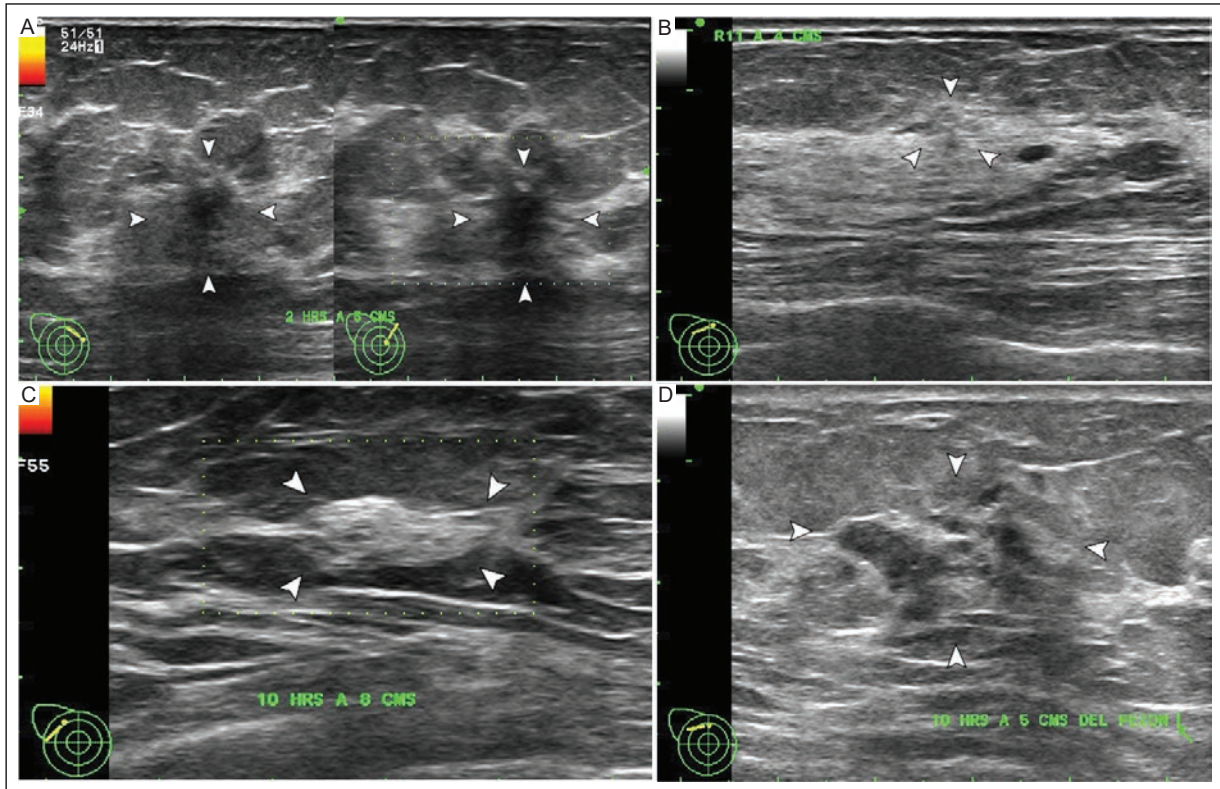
US in grayscale and power Doppler showing the echogenicity of breast NM. A: hypoechoic (arrowheads). B: isoechoic (arrowheads). C: hyperechoic (arrowheads). D: mixed echogenicity (arrowheads).
